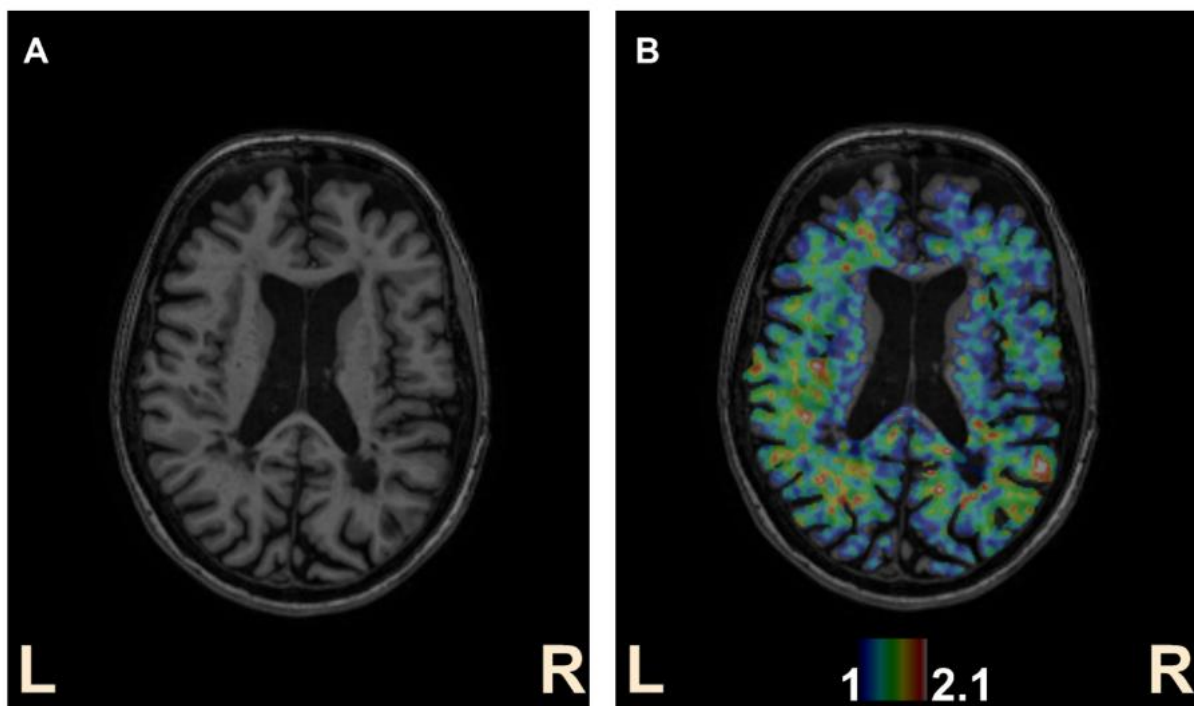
Magnetic resonance and positron emission tomography images of the brain. A) T1 weighted magnetic resonance image of the brain of a MS patient. Lesions can be seen as dark spots. B) TSPO-PET image of the whole brain laid over the magnetic resonance image. [^{11}C]PK11195 was used as the radioligand. Specific [^{11}C]PK11195 is represented on a rainbow scale with blue colour indicating lower DVR and red higher DVR indicating lower and higher microglial activation, respectively. The images are from the brain of a 48-year-old MS patient with a EDSS score of 4. DVR, distribution volume ratio; PET, positron emission tomography; TSPO, mitochondrial 18-kDa translocator protein. Created by Inke Tirkkonen.
